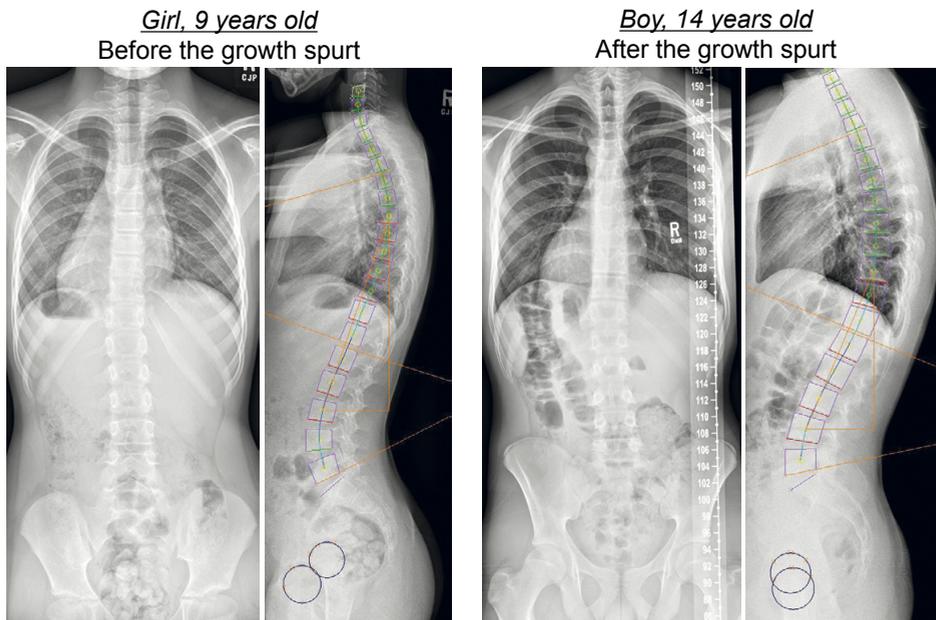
Anterior-posterior and lateral radiographs of two subjects showing the semi-automatic measurement of regional sagittal spino-pelvic parameters and inclination of each individual vertebra.
